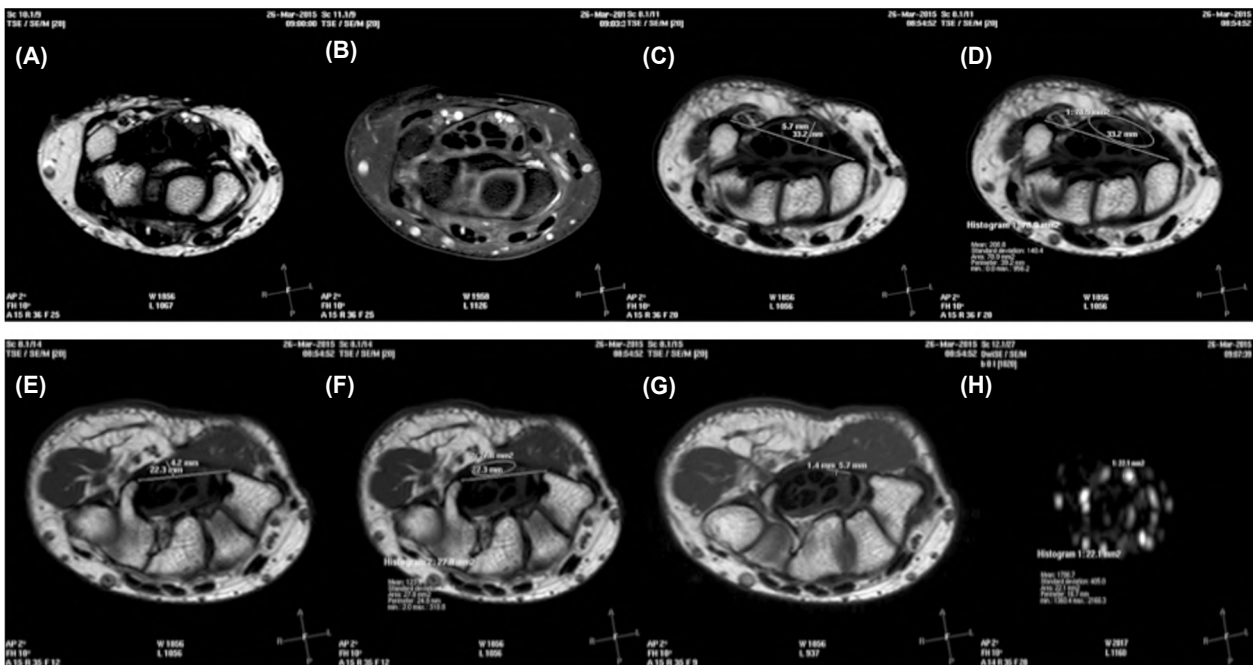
A 41-year-old female patient with history of right hand parasthesia and pain along MN distribution. She had positive Phalen, Tinel and Durkan's tests. On EPS results, she had mild entrapment on MN at the level of CT. (A,B) Axial T2 and PD with fat suppression WIs shows multiple small ganglion cysts were noted at the ulnar side of the MN causing compression on it; the MN was markedly hyperintense compared to the thenar muscle (C,D) Axial T1WIs at the level of CT inlet shows FR bowing height was 5.7mm and bowing area of 78.9mm<sup>2</sup> (E,F) Axial T1 WIs at the level of CT outlet shows FR bowing height was 4.2mm and bowing area of 27.8mm<sup>2</sup> (G) Axial T 1 WI shows MN flattening ratio at the level of hook of hamate was 4.07 (H) Axial DWI shows CSA of the MN at the level of pisiform bone was 22.1mm<sup>2</sup>.
